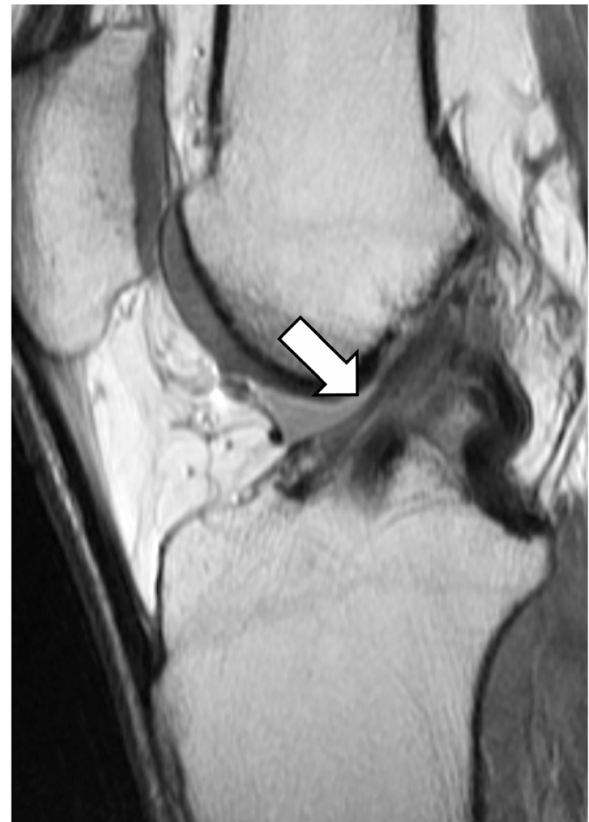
The arrow indicates a partially visible anteromedial graft in sagittal proton-density magnetic resonance imaging.
